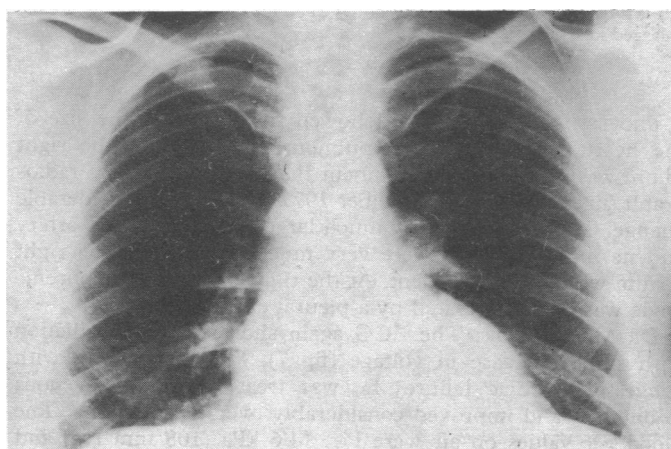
Chest radiograph taken on 14 October 1974 showing slightly enlarged heart.
